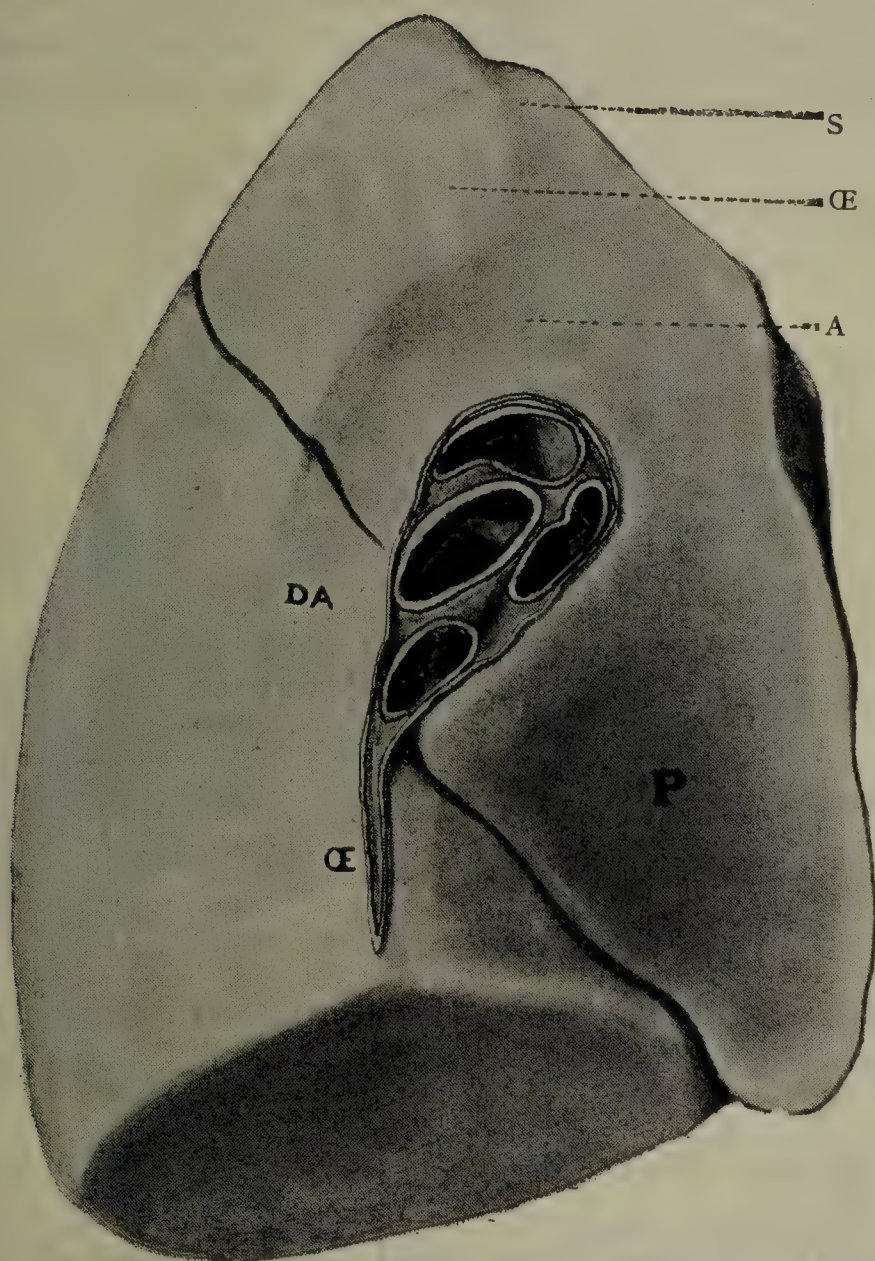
MEDIASTINAL ASPECT OF LEFT LUNG.
